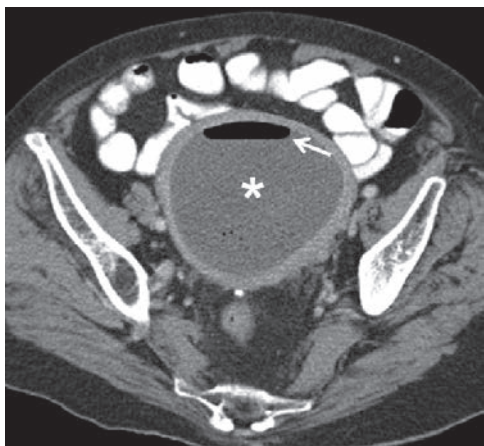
A 73-year-old woman with endometrial cancer presented with pelvic pain, fever and vaginal bleeding. Axial CT scan performed with enteric and IV contrast demonstrates a markedly distended endometrial cavity containing fluid (*). There is air also present, with an air-fluid level (arrow). In a febrile patient, this is highly suggestive of infection/endometritis. At D&C, blood and pus were drained from the uterine cavity compatible with pyohematometra.
